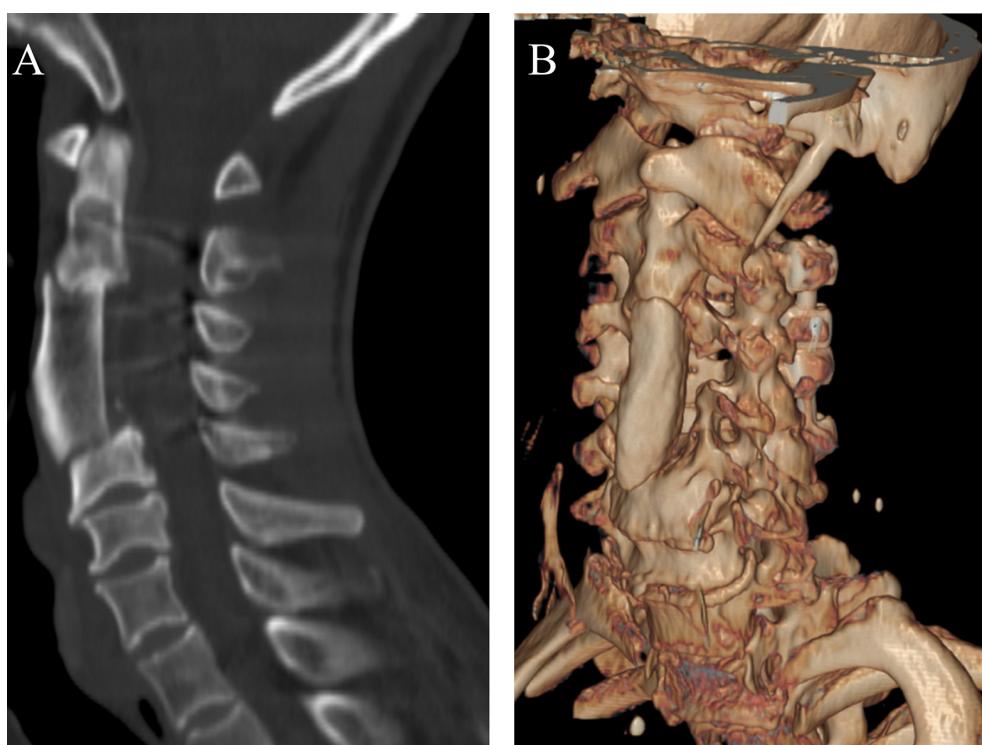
CT image of the spine at 3 months postoperatively. A, Blurred structural bone graft with autologous iliac bone graft, good fusion, good fusion of the interlaminar bone graft in the posterior column, internal fixation in place, and improvement of cervical kyphosis. B, 3D CT reconstruction.
